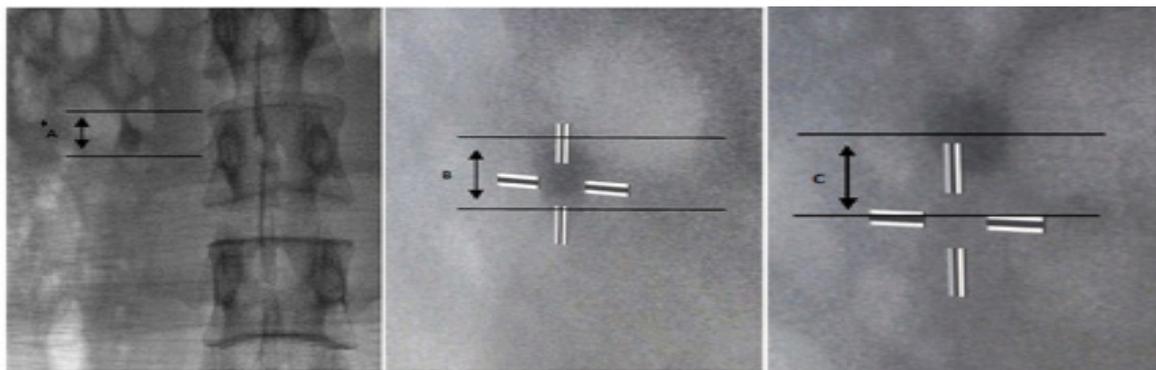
The method used to measure the actual mobility (M). A: Craniocaudal size of the stone on kidney-ureter-bladder X-ray, B: The size of the stone under fluoroscopy, C: The mobility of the stone with respiration. $M=A \times C/B$ (Calculation of actual mobility by calculating the ratio of the actual size of the stone on kidney-ureter-bladder X-ray and its size on fluoroscopy).
